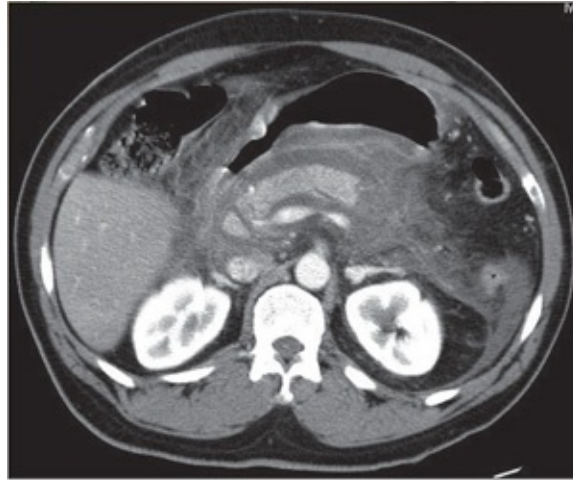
CT image of acute pancreatitis.
